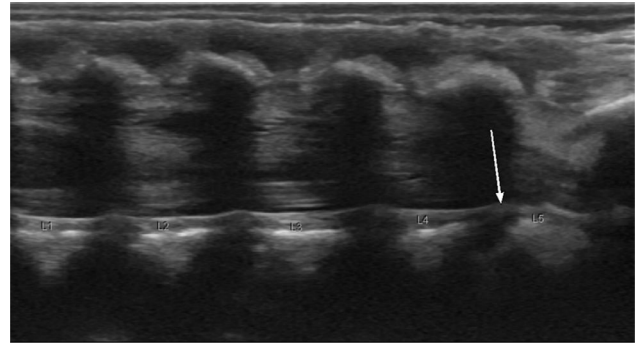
Sagittal ultrasound image of the lumbar spine demonstrating the vertebral anomaly at L4-L5 as narrowing of the disc space and tethering of the vertebral bodies (white arrow).
